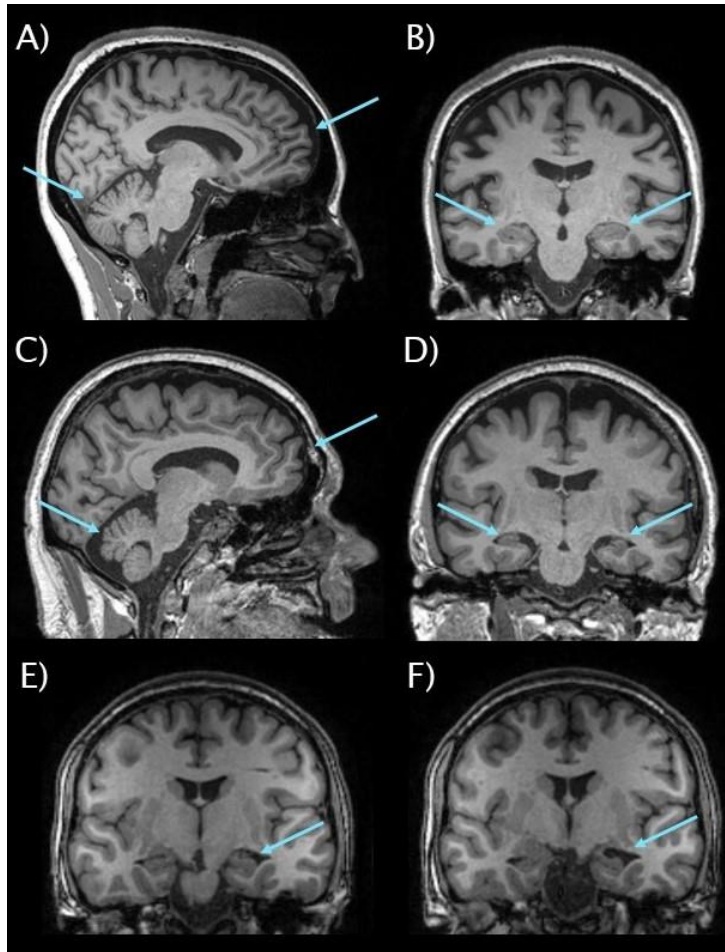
Structural brain changes in DS. Representative T1-weighted MRI sagittal (A, C) and coronal (B, D-F) sections. A, B) a 44-year-old euploid control and C, D) a 45-year-old individual with DS without dementia. Arrowheads highlight differences in the frontal cortex, cerebellum, and hippocampus. E, F) a 36-year-old individual with DS without dementia, Arrowheads highlight the presence of a left incomplete hippocampal inversion.
